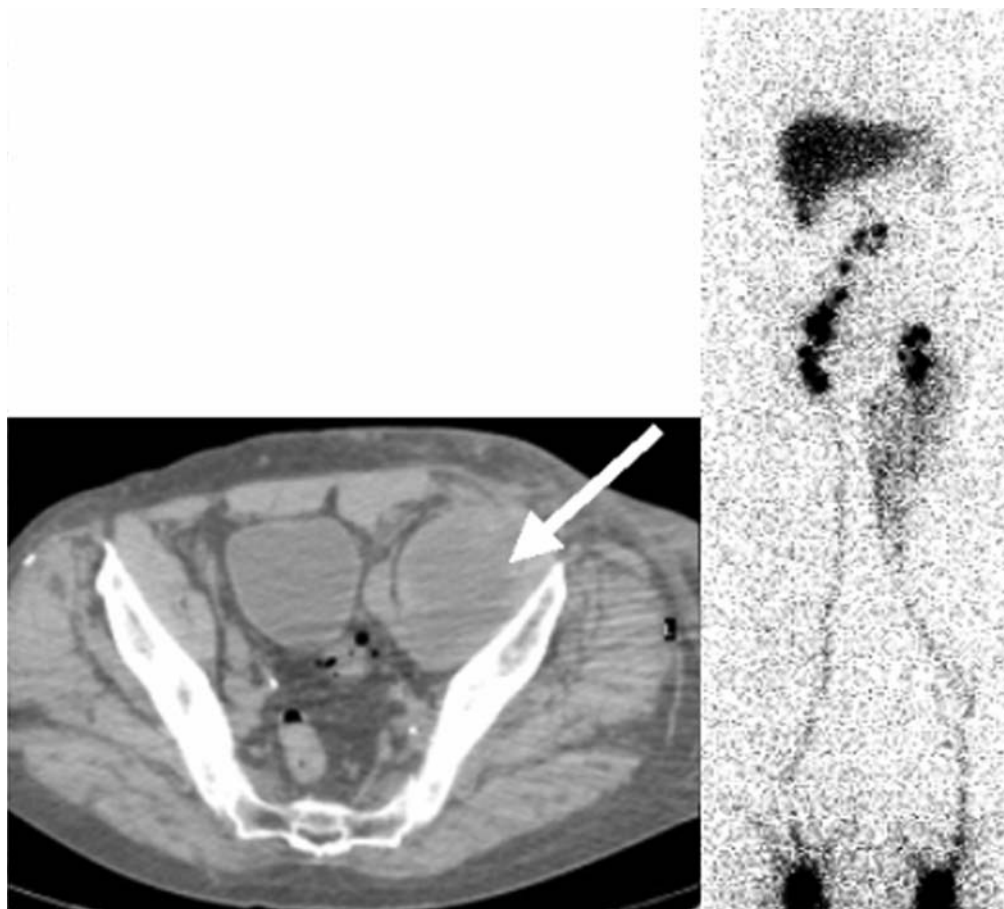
Large synovial cyst (*arrow*) arising from left hip after arthroplasty resulted in stretching and compression of lymphatic and blood vessels and was accompanied by LE (demonstrated by lymphoscintigram in *right panel*) that responded to decompression of the cyst.
